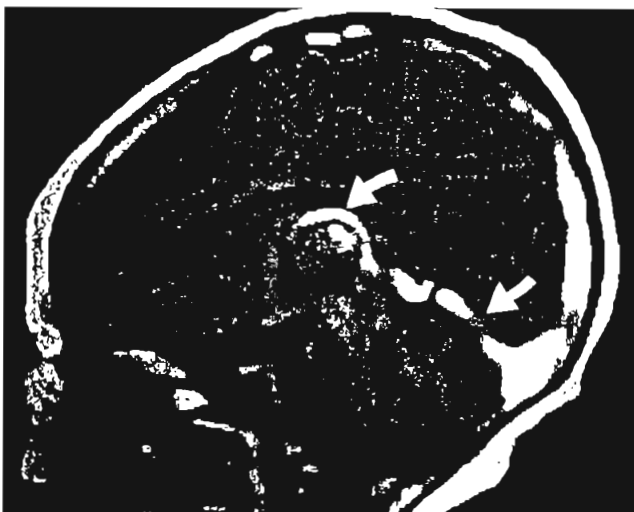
Sagittal T1-weighted MR image revealing thrombosis of the sagittal sinus (high signal over the convexity of the hemisphere), straight sinus (arrow), and internal cerebral veins (curved arrow) as a complication of bacterial meningitis in an infant. (From Connor SEJ, Jarosz JM: Magnetic resonance imaging of the cerebral venous sinus thrombosis. *Clin Radiol* 2002;57:449-461.)
